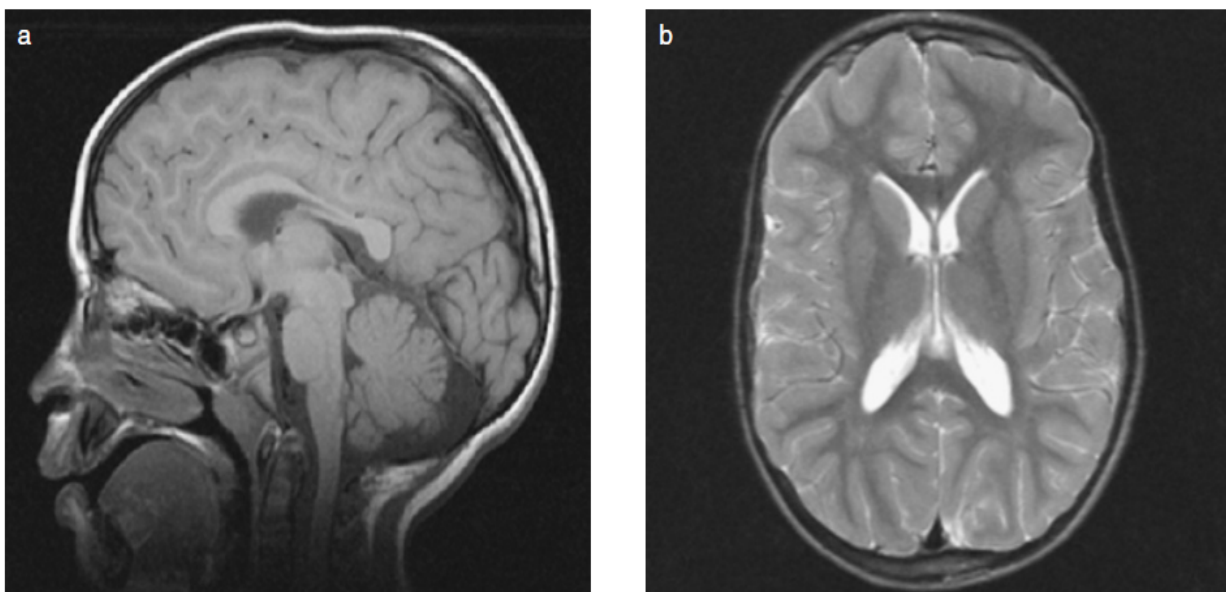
MRI aged 7 years 3 months. Minimal global lack of white matter bulk, with some thinning of the posterior region of corpus callosum ⁸⁹.
